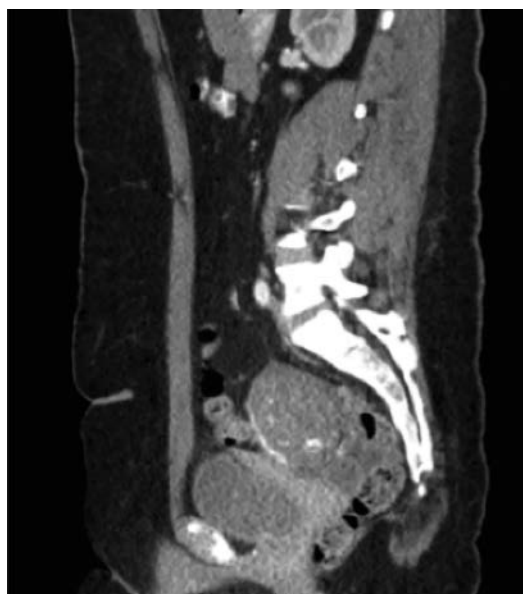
Computed tomographic scan showed left ovarian mass measuring $9.2 \times 8.7 \times 10$ cm with differing densities.
